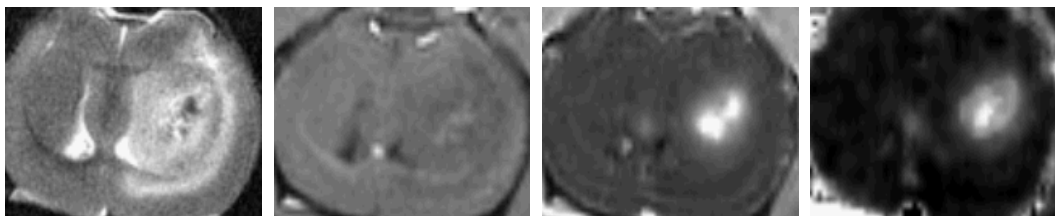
Representative T2-weighted image, T1-weighted image pre and post contrast, and permeability map.
